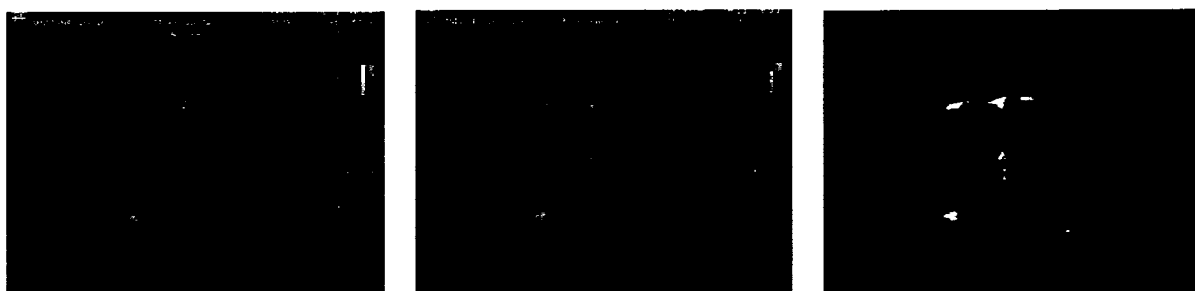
An example of an color Doppler ultrasound image before and after segmentation (right and middle) and after masking (left).
